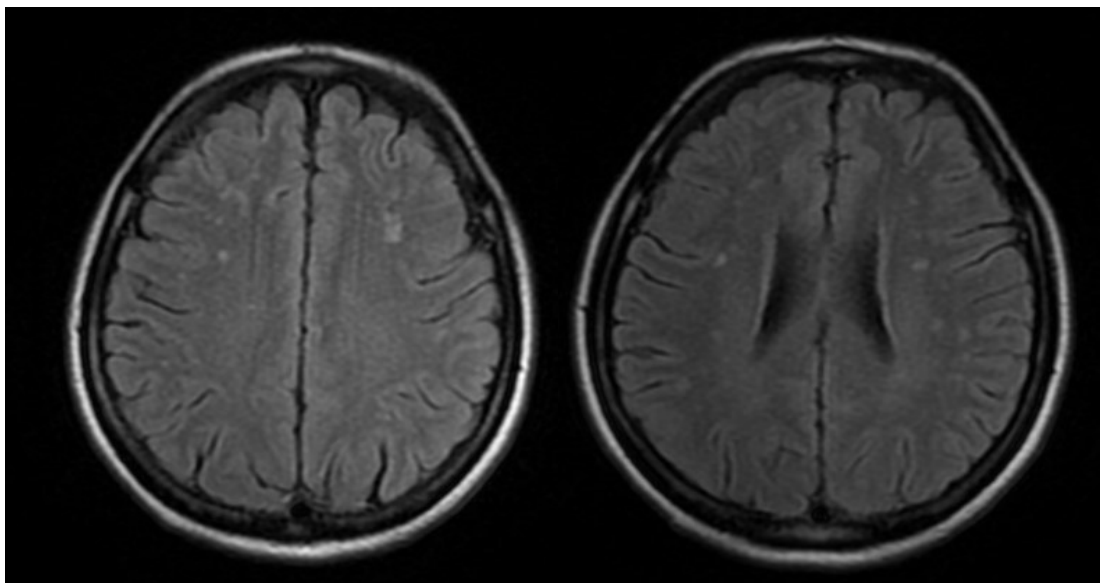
Axial FLAIR MRI images shows small multiple bright focus(white matter hyperintensity) at the bilateral periventricular and centrum semiovale regions.
